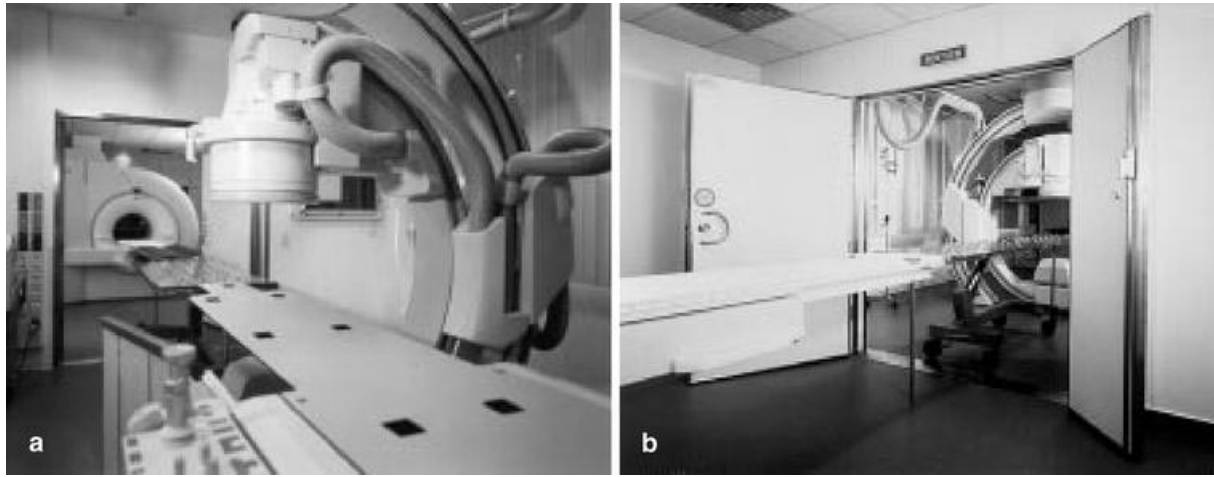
View from inside the hybrid system a toward the MRI unit, or b out of the MR suite. A newly developed, mobile connecting table with integrated roller on the table top enables immediate positioning of the patient in either unit within 10 s without the need for transposition
